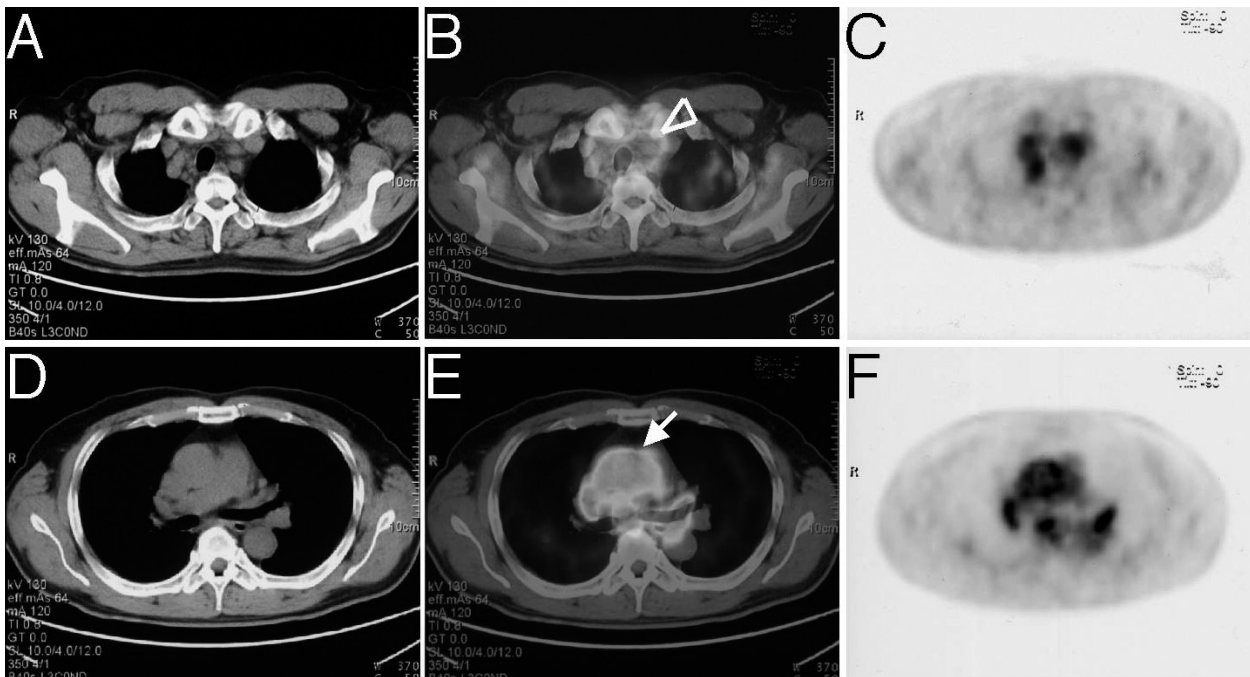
¹⁸F-FDG PET coregistered with computed tomography
